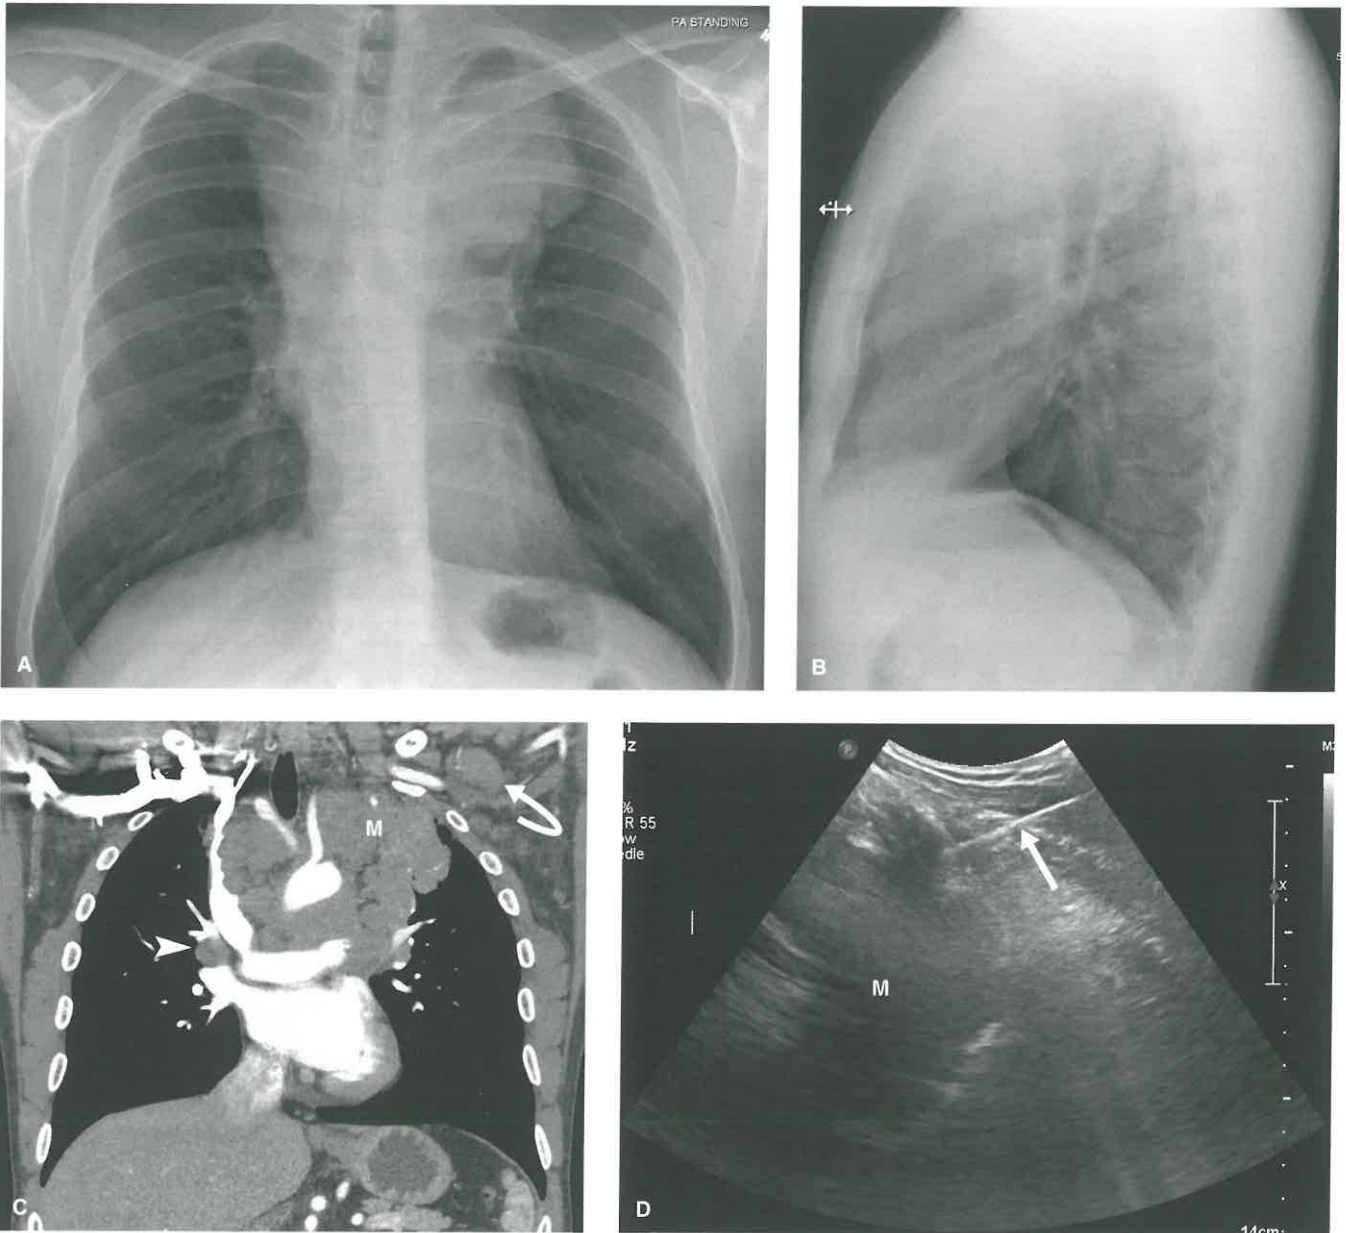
Hodgkin Lymphoma. A, B: Posteroanterior (A) and lateral (B) chest radiographs in a 35-year-old man shows a large, lobulated anterior and superior mediastinal mass. C: Coronal contrast-enhanced CT at the level of the aortic arch shows a large superior mediastinal mass (M) encompassing the arch and great vessels. Note enlarged right hilar (arrowhead) and left axillary (curved arrow) lymph nodes. D: Ultrasound-guided core needle biopsy shows the mass (M) with biopsy needle (arrow) at edge of lesion. Core biopsy demonstrated nodular sclerosing subtype of Hodgkin disease.
